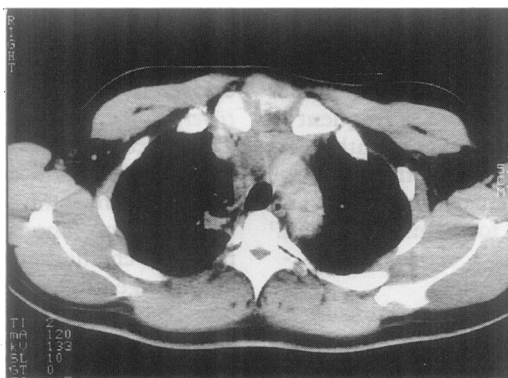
Figure CT scan of the chest shows a retrosternal mass invading and causing lytic defects in the manubrium
